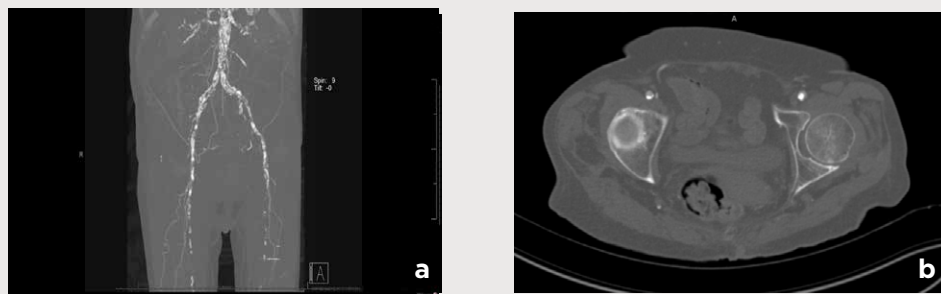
The coronal CT angiogram reconstruction demonstrated the severe aortoiliac occlusive disease (a). The axial view of bilateral common femoral arteries showed extensive atherosclerotic disease burden, especially in the left common femoral artery (b).
